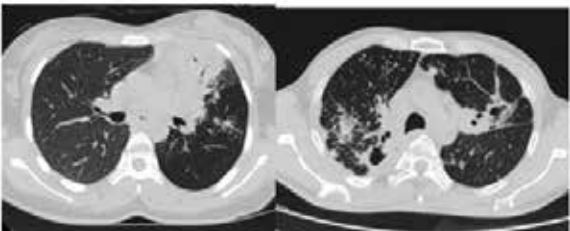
(a) Axial thin slice CT image in 18 yr old female patient on MDR-TB treatment since 2 days showing consolidation of the left lingular segment and tree-in-bud appearance. (b) Axial thin slice CT in 45yr old male patient on MDR-TB treatment since 5days showing multiple alveolar nodules with tree-in-bud appearance and a thin walled cavity communicating with the upper lobe bronchus with surrounding consolidation.
